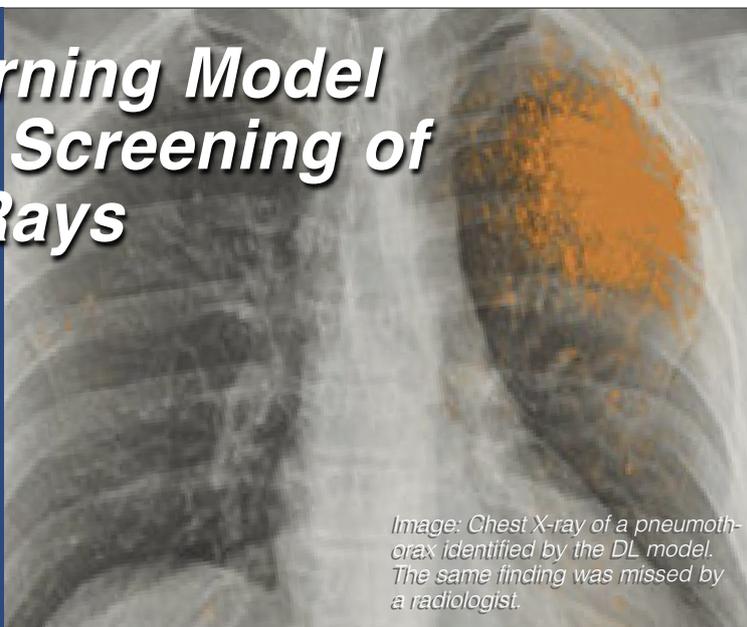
Chest X-ray of a pneumothorax identified by the DL model. The same finding was missed by a radiologist.
